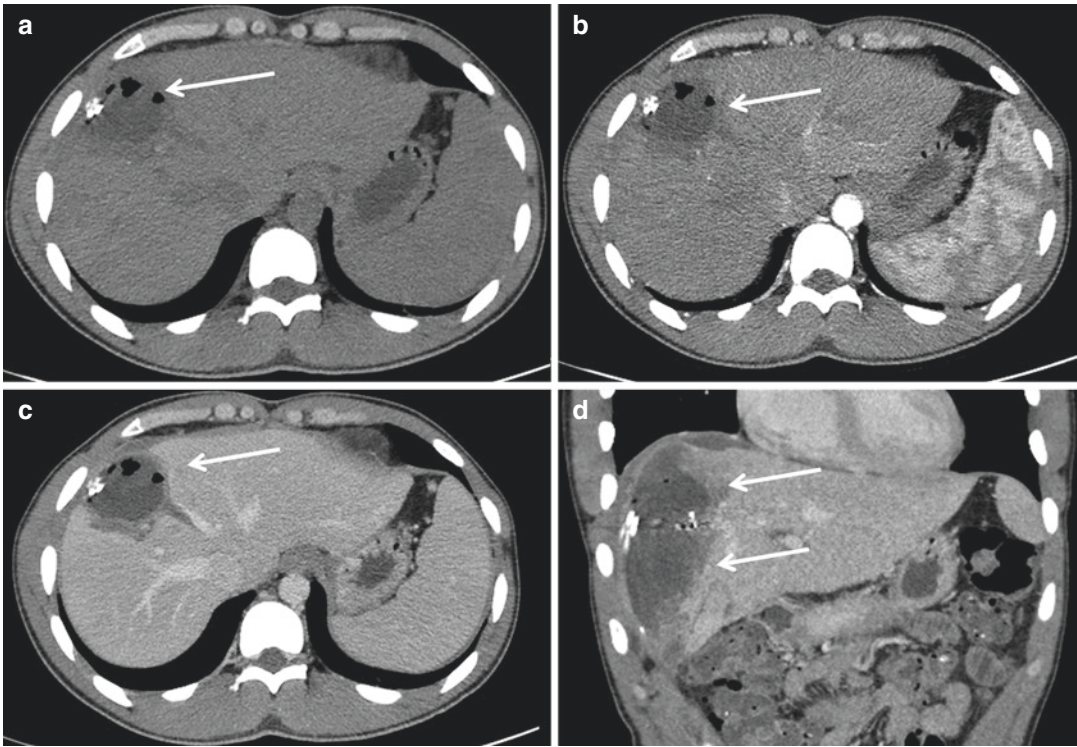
Liver abscess 20 days after trauma. (a) Unenhanced CT scan, (b, c) CE-MDCT in the arterial (b) and venous (c) phases. (d) Coronal reconstruction. CT
